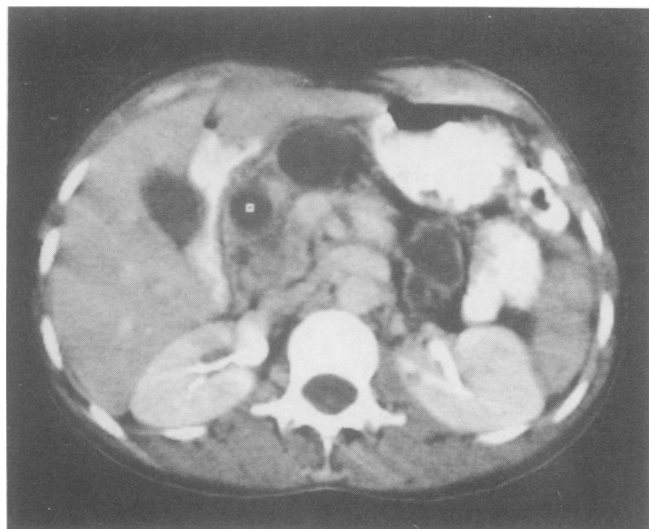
Computed tomographic scan of abdomen reveals loculated, multicystic mass in region of pancreas.
